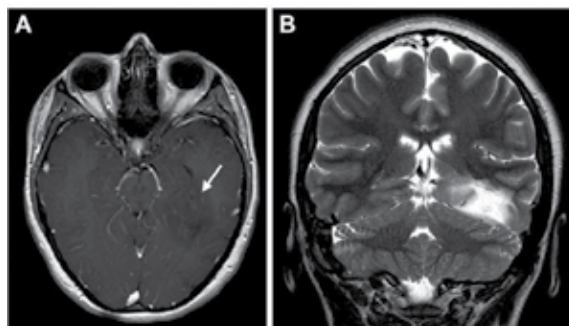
Magnetic resonance imaging (MRI) of 20-years old woman. A – OA, T1-weighted sequence after gadolinium contrast enhancement (arrow); B – Id, hyperintensity in T2-weighted sequence.
